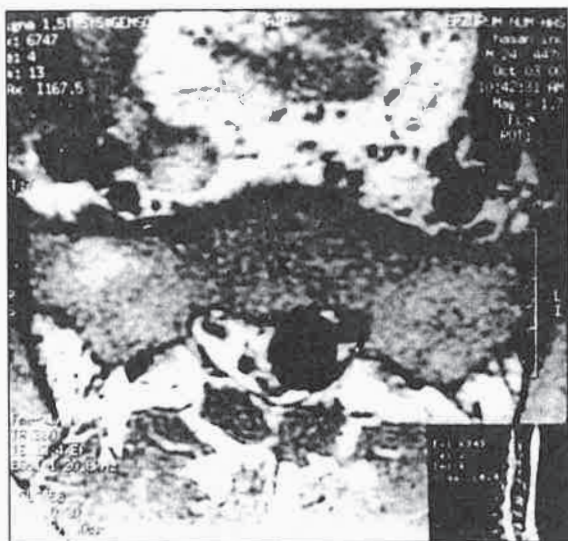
T1-weighted axial image of sacral Tarlov cyst.
